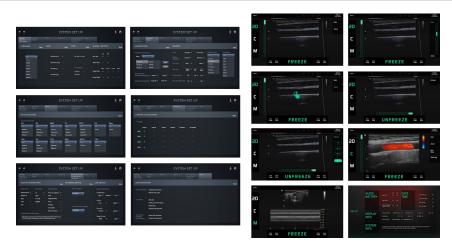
System set up UI concept of wireless ultrasound scanner (left), UI concept of modified smart IT device.
